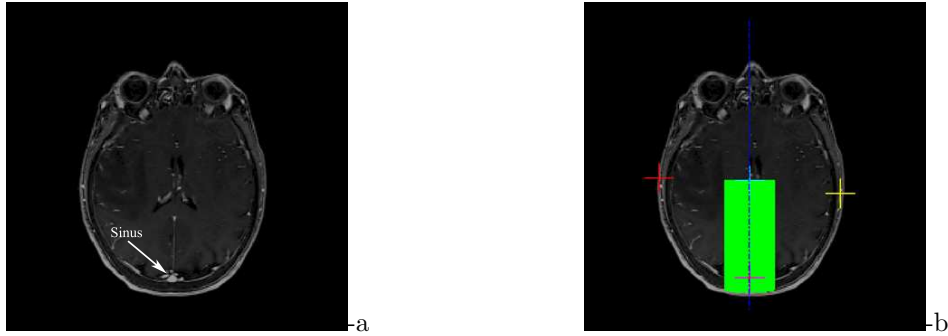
Seed point search region over a T1-MRI slice for sinus map extraction.
